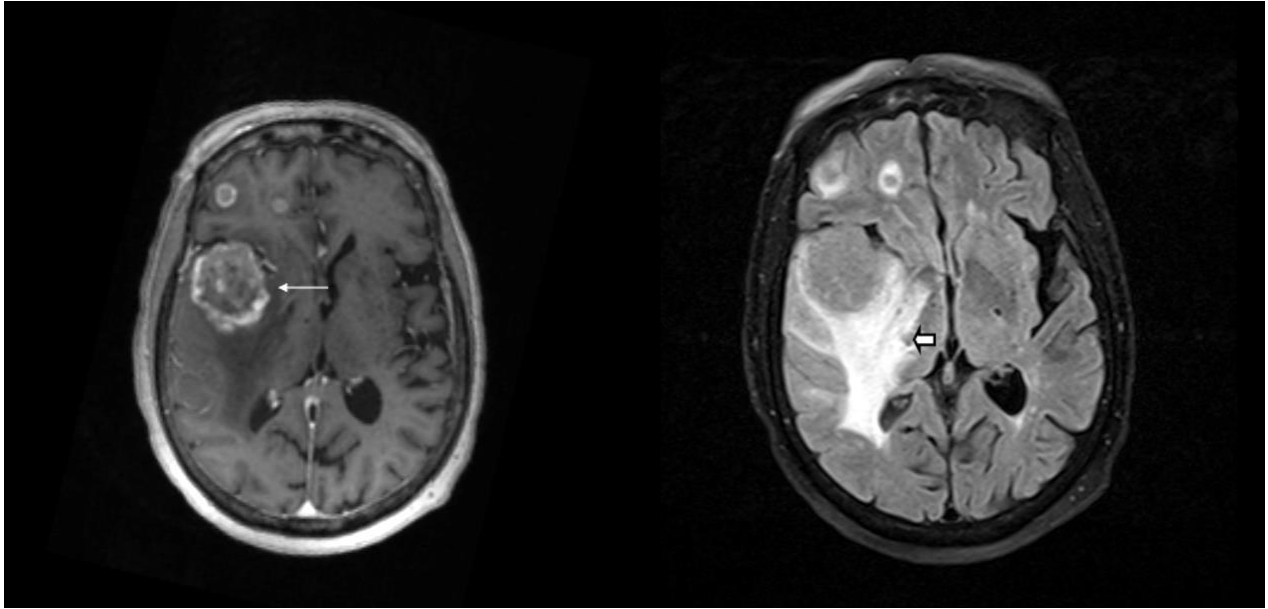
Axial T1 MPRAGE sequence with contrast demonstrates multiple enhancing intraparenchymal lesions in the right temporal and frontal lobes due to metastatic disease (largest lesion labeled by thin long arrow). A FLAIR axial image demonstrates adjacent vasogenic edema with mild mass effect most prominently along the right temporal lobe (short arrow).
